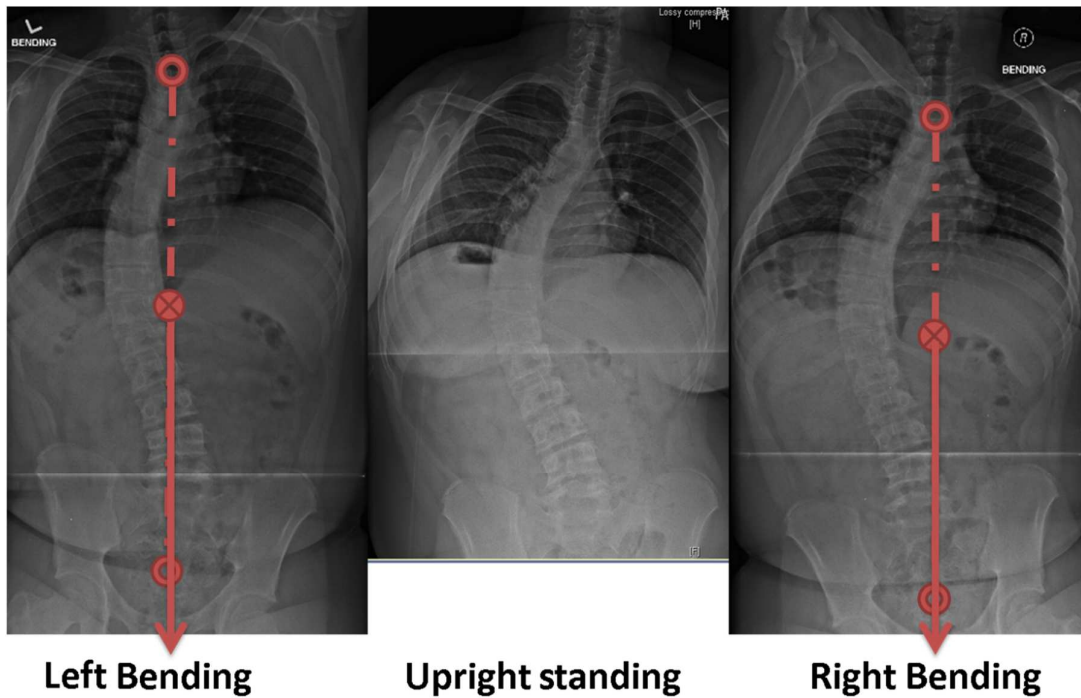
X-ray images of the scoliosis male subject in upright standing, bending right and left postures
